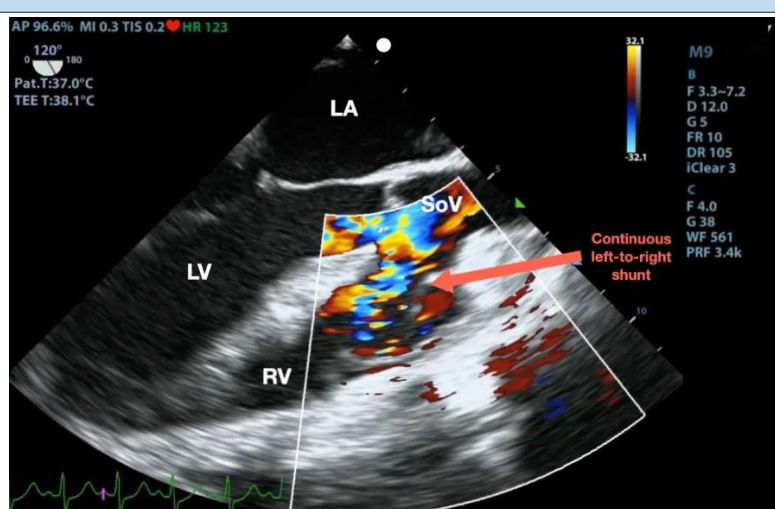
Mid-esophageal (ME) long axis 2D (LAX) view with color-flow Doppler in TEE revealing turbulent flow from sinus of Valsalva to the right ventricle. LA, Left atrium; LV, Left ventricle; Ao, Aorta; RV, Right ventricle.
